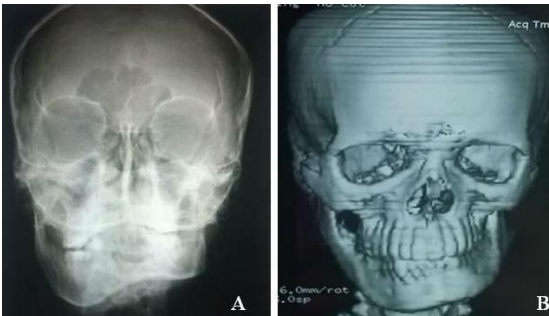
PA view (a) and 3D CT view (b) revealed hypoplasia of mandible, maxilla and mid facial bones on left side
